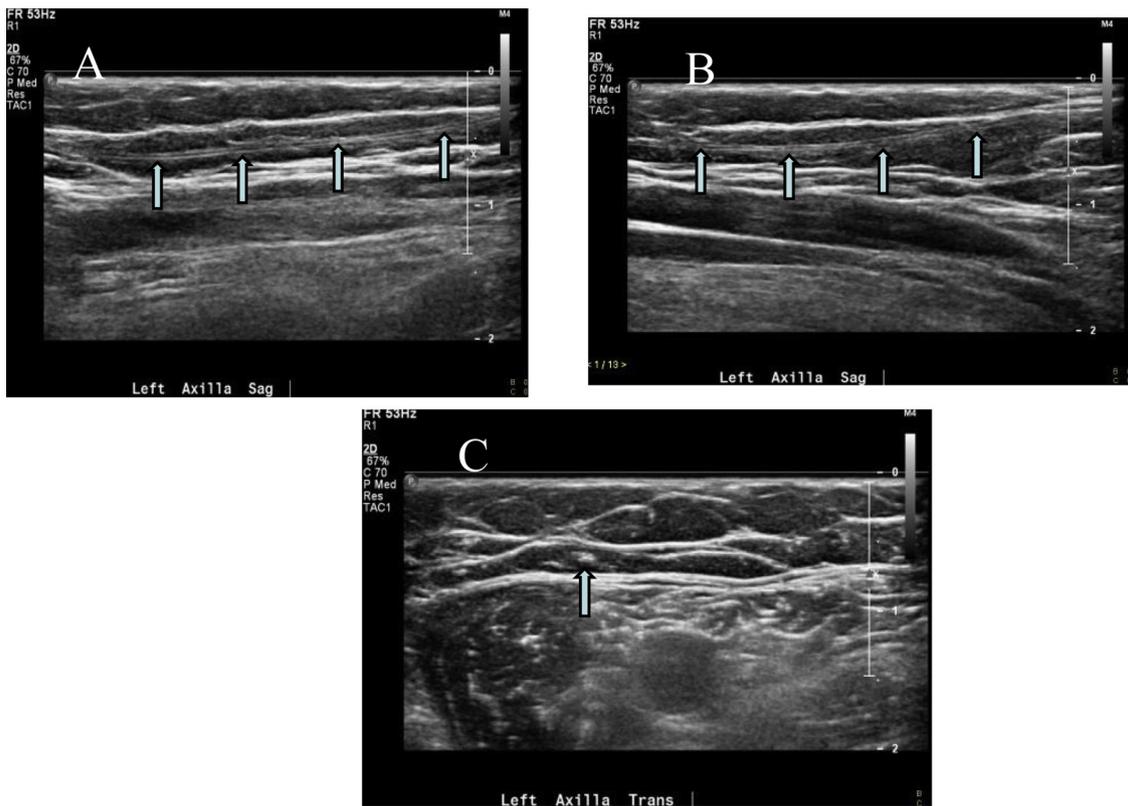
44-year-old woman 10 months after mastectomy and SLNB for treatment of breast cancer, with chronic palpable axillary cords. A: sagittal ultrasound of a cord in the axilla with trilaminar appearance, B: a second axillary cord, sagittal view, C: transverse view of an axillary cord.
